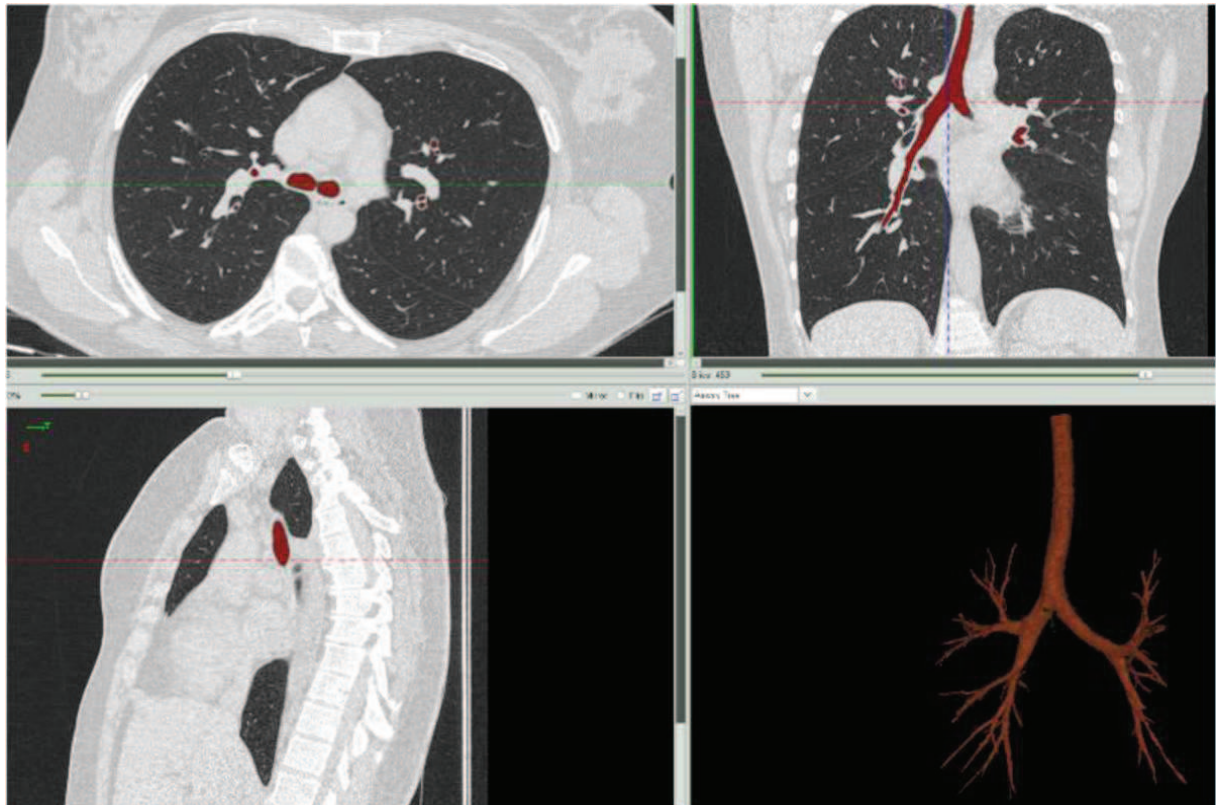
Images relevant to phases of post processing procedure of lung CT scans.
